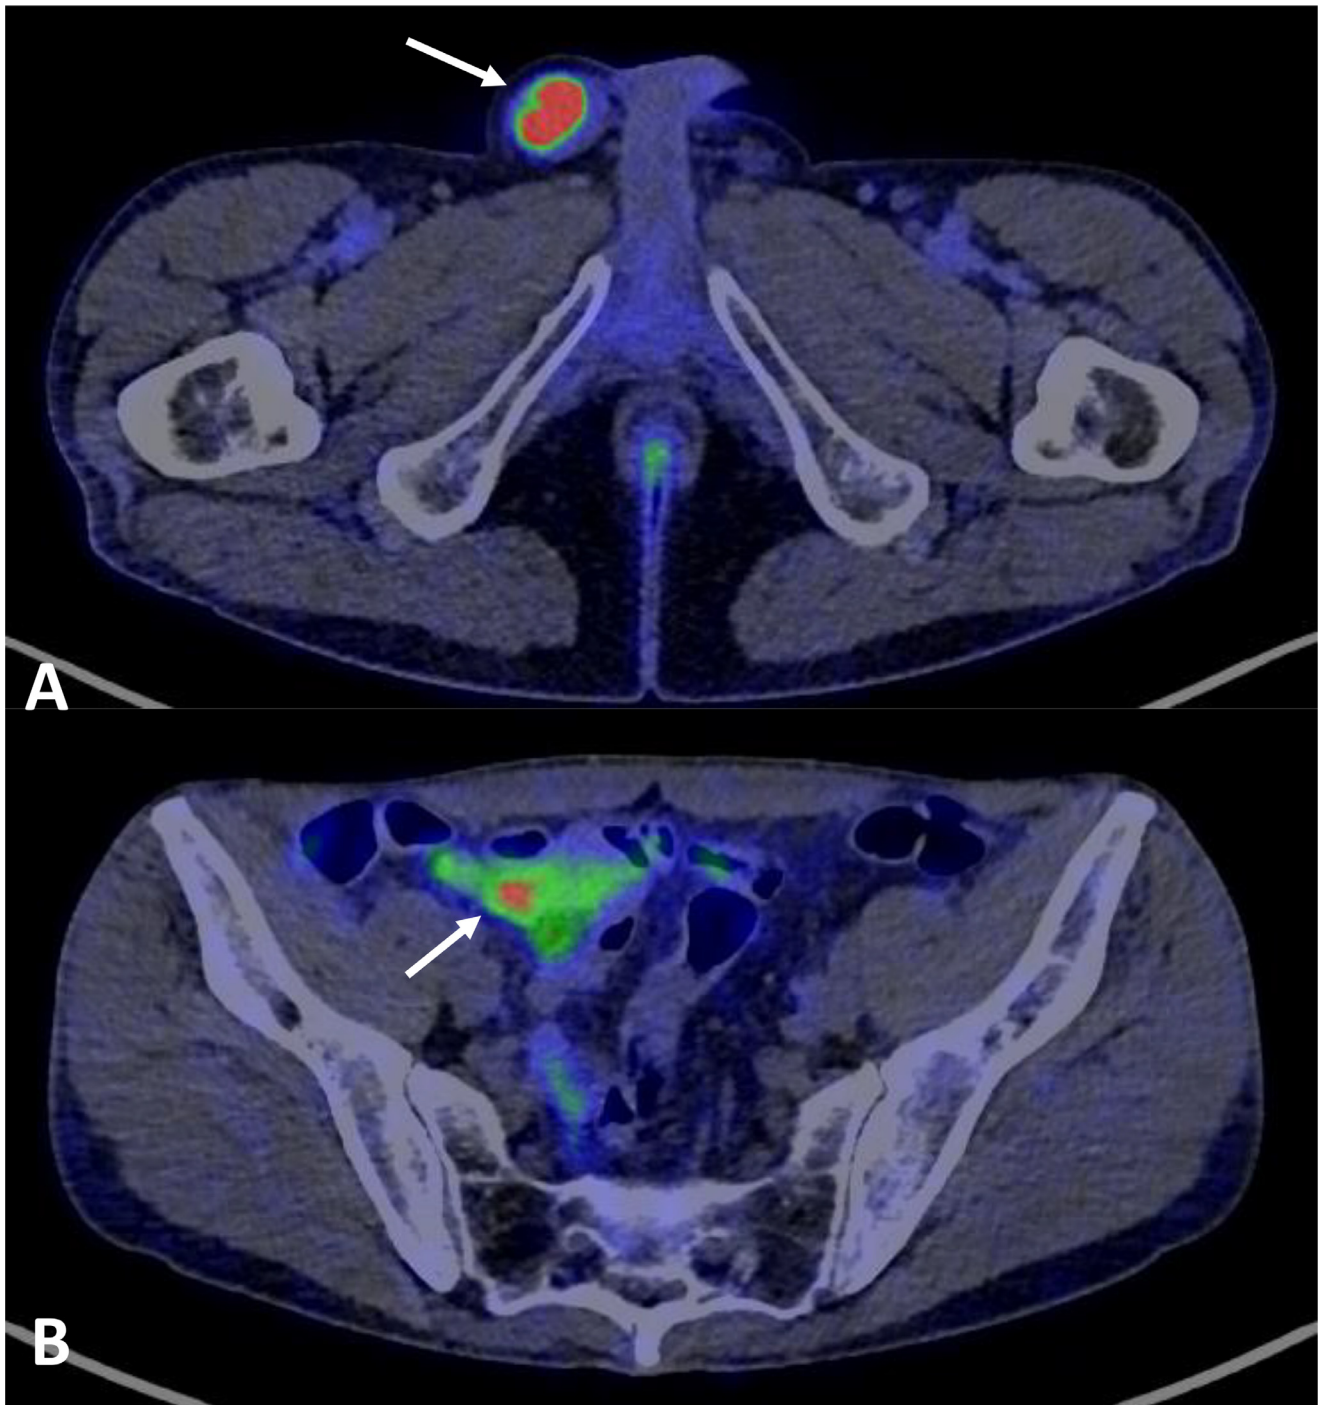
Axial reconstruction of Ga-Dotatate PET-CT. (A) Markedly increased tracer uptake within the right inguinal paratesticular soft tissue. (B) New increased focal uptake within the terminal ileum at the site of the primary small bowel neuroendocrine tumor which was not seen on the FDG PET-CT.
